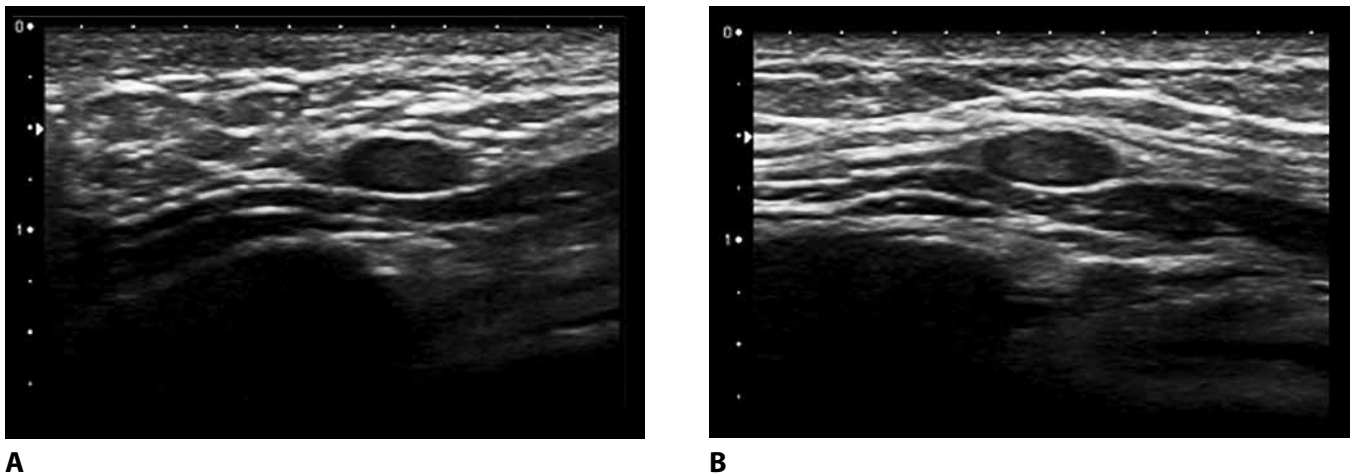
LYMPH NODES — INTRAMAMMARY. Small, enhancing, oval mass on MR thought to be an INTRAMAMMARY LYMPH NODE is confirmed on MRI-directed US examination. The hypoechoic cortex and echogenic hilus are identifiable on orthogonal views (*a* and *b*).
